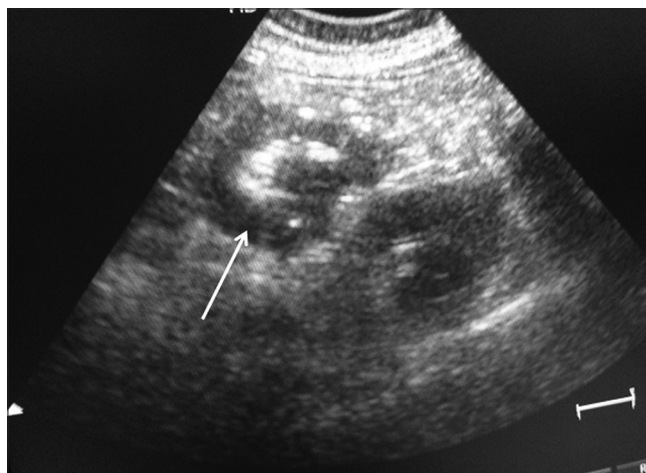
Transverse view of intussusception in ultrasonography producing the "crescent in doughnut" sign (white arrow)
